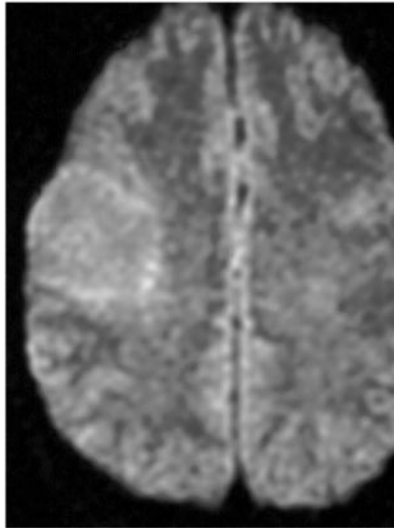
Oligoastrocytoma. (a) Axial T1-weighted MR image shows a hypointense mass (arrow) in the right frontal lobe. (b) Axial T2-weighted MR image shows heterogeneity of the mass with exophytic extension. (c) Axial diffusion-weighted MR image shows that the mass is predominantly isointense relative to the adjacent gray matter. (d) Axial contrast-enhanced T1-weighted MR image shows no enhancement of the mass.
